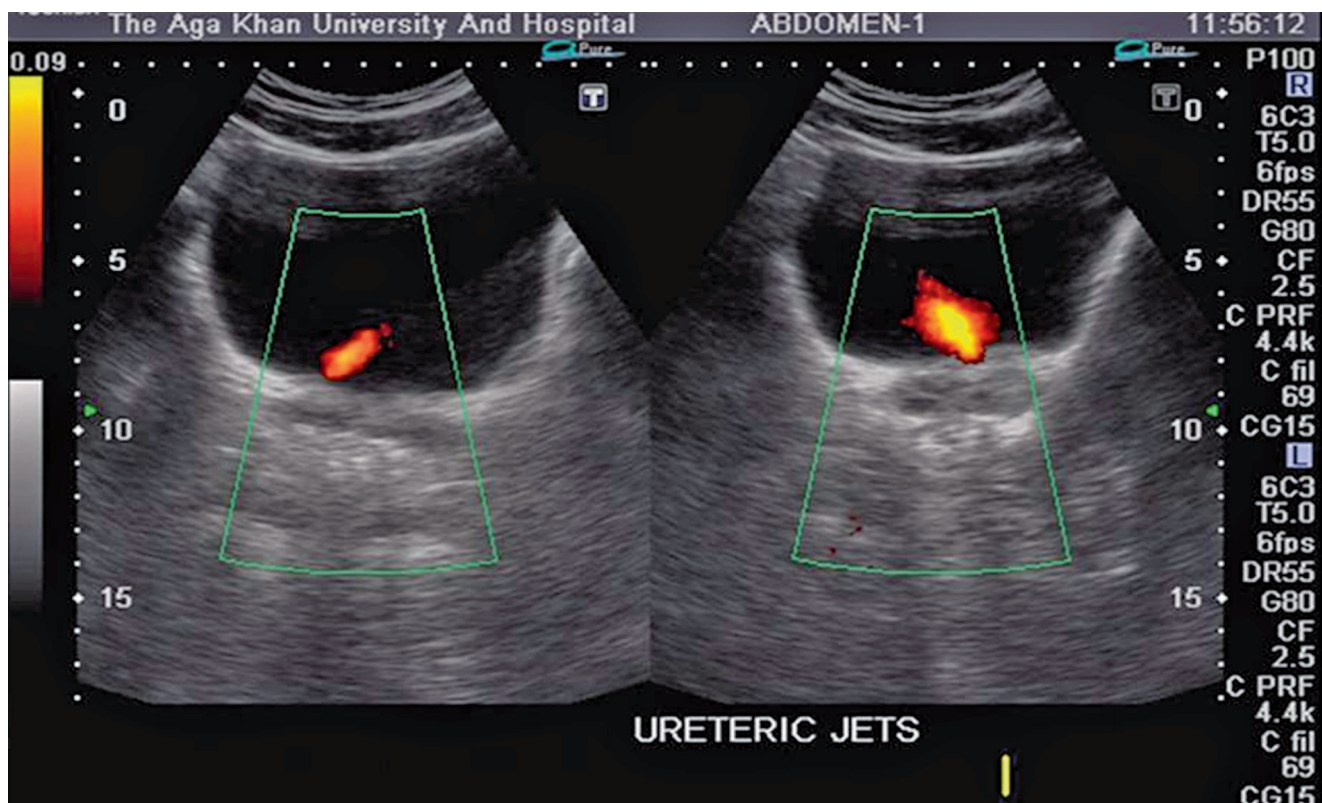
Ultrasound showing ureteral jets
